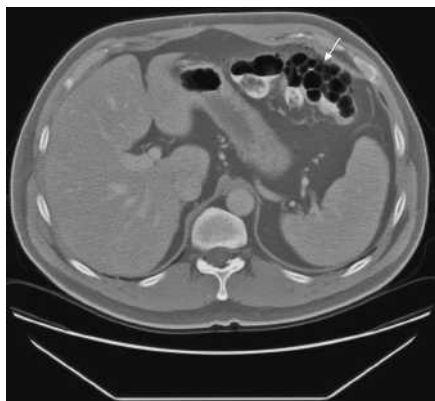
A 47-year-old man presented with a 2-week history of mid-abdominal pain. He denied having any fever, chills, nausea, vomiting, or diarrhea. Computed tomography of the abdomen revealed numerous air-filled cysts involving the splenic flexure of the colon (arrow), a finding consistent with pneumatosis coli. A colonoscopy examination was then performed, which revealed sigmoid diverticulosis.
